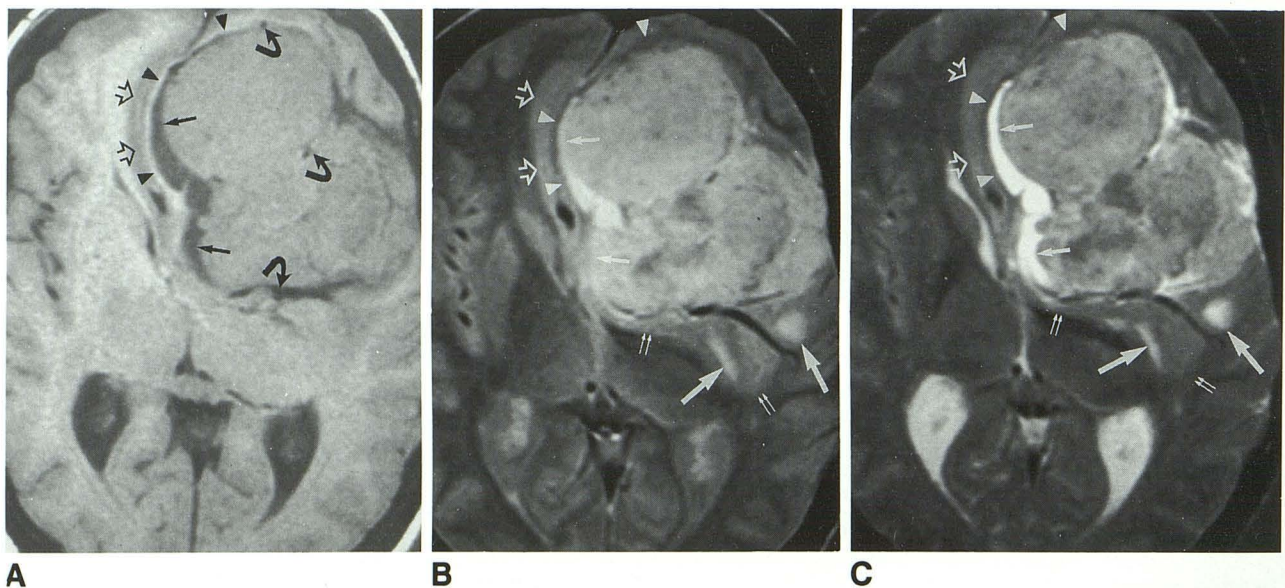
A, Axial noncontrast T1-weighted MR scan (TR = 600 msec, TE = 20 msec) demonstrates a well-delineated globular left frontal mass that is isointense to gray matter. A low-intensity rim, the CSF cleft (*small single black arrows*), surrounds the mass. A thin, intermediate signal fibrous capsule (*black arrowheads*) is interposed between the fluid-filled cleft and the adjacent displaced cortex (*open black arrows*). Note the presence of punctate and curvilinear flow voids (*curved black arrows*) within (dural vascular supply) and around the mass (pial arterial supply, draining veins).
